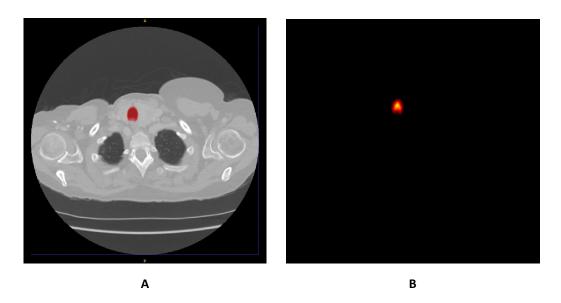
A: An axial slice of a chest CT scan with a trachea segmentation. B: A distance transformation $D_z(x, y)$ of the same trachea segmentation. I used a local maximum as the start point of the centreline.
